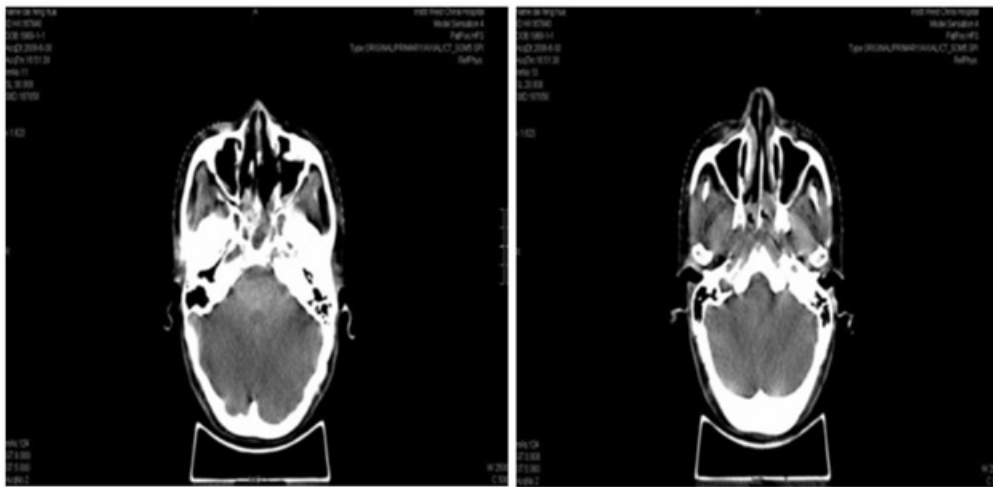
Picture before the first relapse June 30, 200 CT
